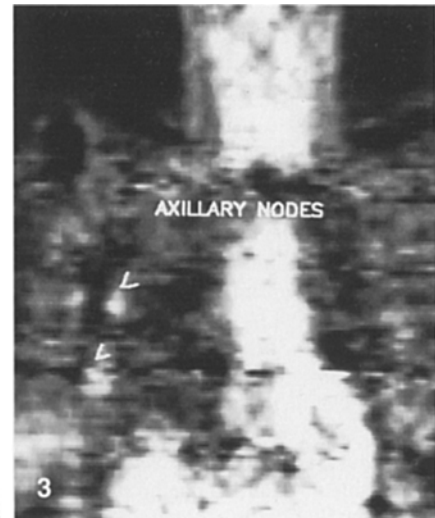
Anterior ^{18}F -FDG PET images showing focal areas of moderate uptake in the right axilla without evidence of tumor by surgical node dissection (false-positive finding)
